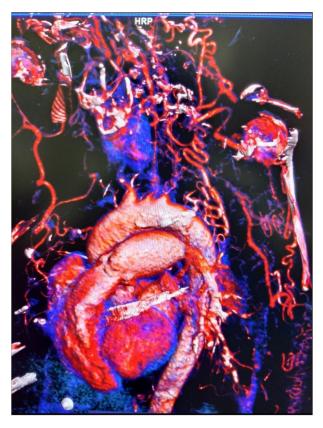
CT Aortography of the patient showing narrowing of major vessels at the origin
